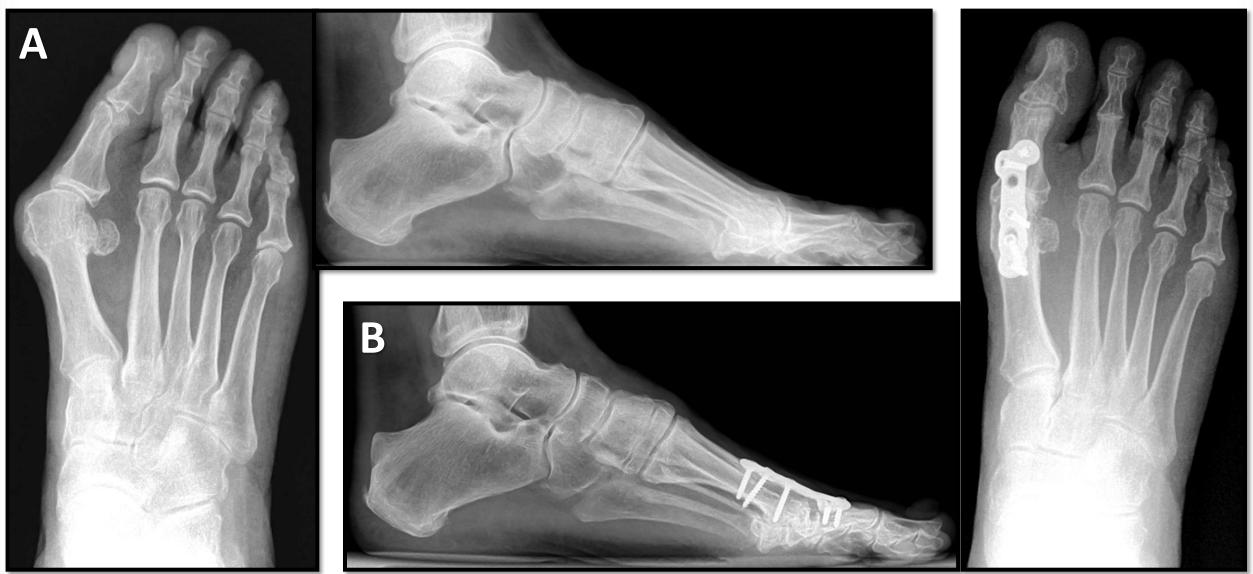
A) Pre-operative AP and Lateral radiographs of patient with severe HAV. B) Post-operative AP and Lateral radiographs.
